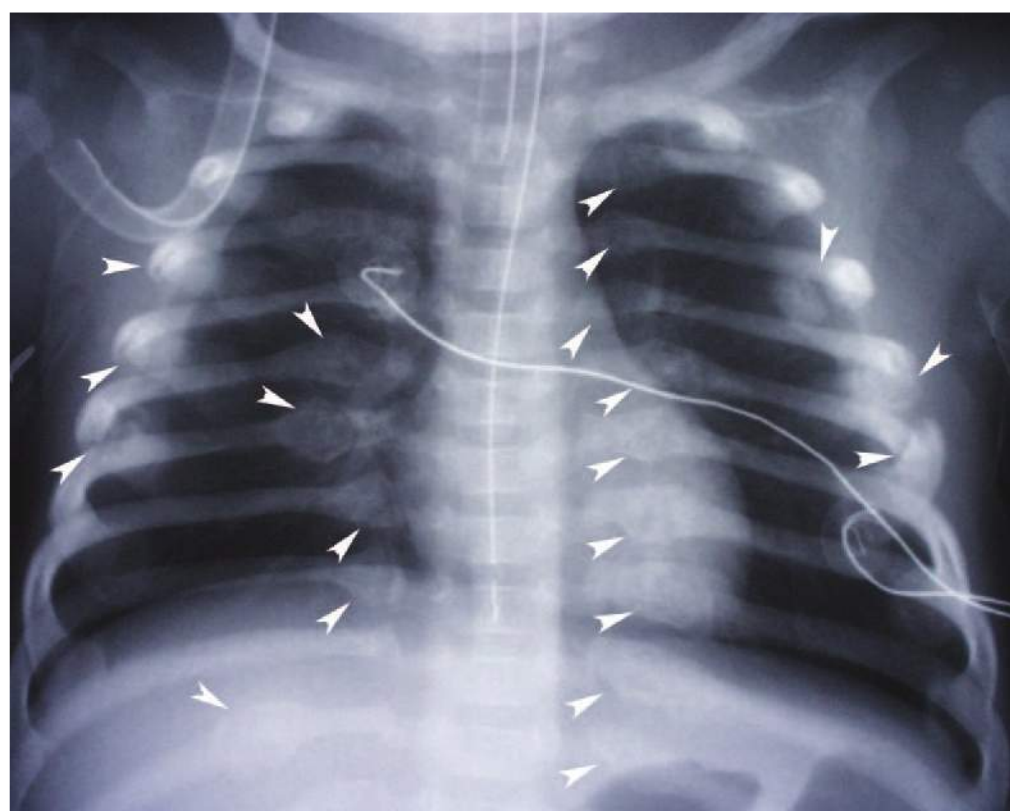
■ Posterior Rib Fractures—Healing. This A/P chest x-ray demonstrates multiple, bilateral, acute, and healing rib fractures in the posterior portion of the ribs adjacent to the spine (arrowheads). Posterior fractures result from levering of the ribs against the transverse processes of the vertebrae. (Photo contributor: Cincinnati Children’s Hospital Medical Center.)
